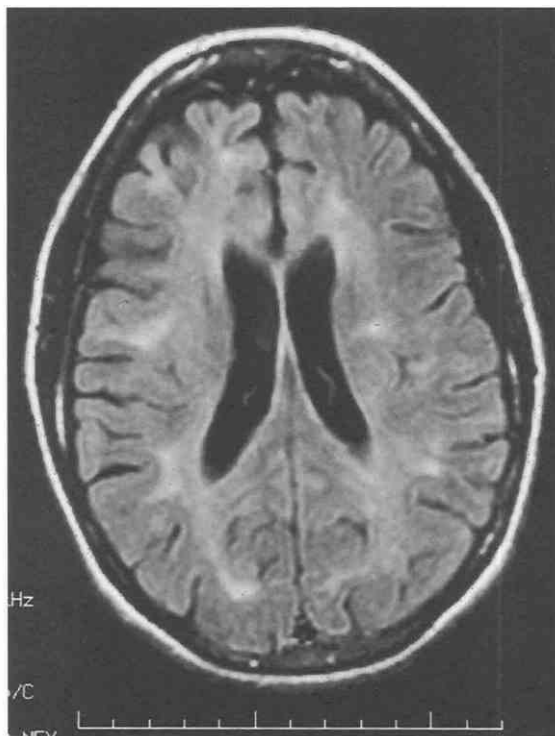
Multiple sclerosis (MS), as shown on a fluid-attenuated inversion recovery (FLAIR) MR image; the patient is a 36-year-old woman with relapsing-remitting MS. Note the conspicuity of the numerous bilateral periventricular white matter lesions.
